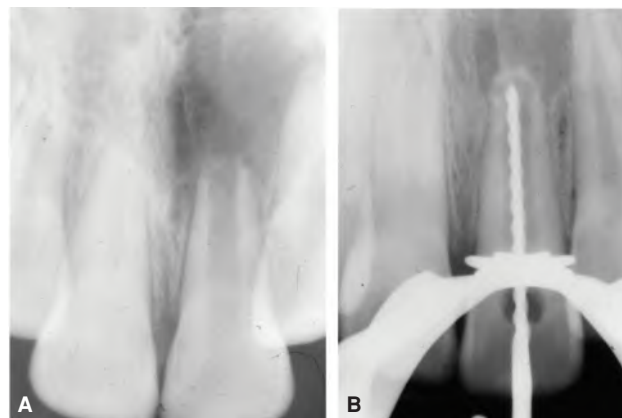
Radiographic images of a maxillary left central incisor in an 8-year-old patient with a history of trauma. A. initial radiograph shows an open apex and a large periapical lesion. Calcium hydroxide was replaced two to three times over a six-month period. B. Radiograph obtained at follow-up shows formation of an apical barrier that is visible radiographically and detectable with an endodontic instrument. (Courtesy of Dr. Leif K. Bakland, Loma Linda, CA, U.S.A.)
